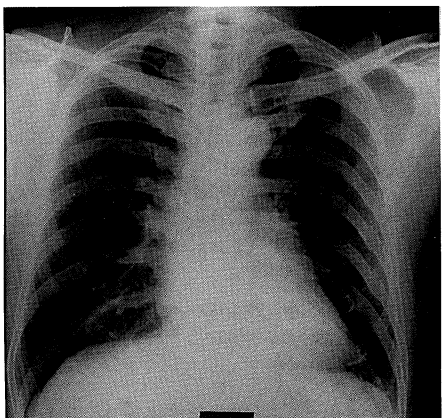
A serial chest X-ray film, showing a localized round bulge on the left cardiac border, suggested a mediastinal mass initially. The abnormal shadow has been gradually enlarging. (A). Chest X-ray film taken on admission. (B). Chest X-ray film taken 3 months before admission. (C). Chest X-ray film taken 6 months before admission.
